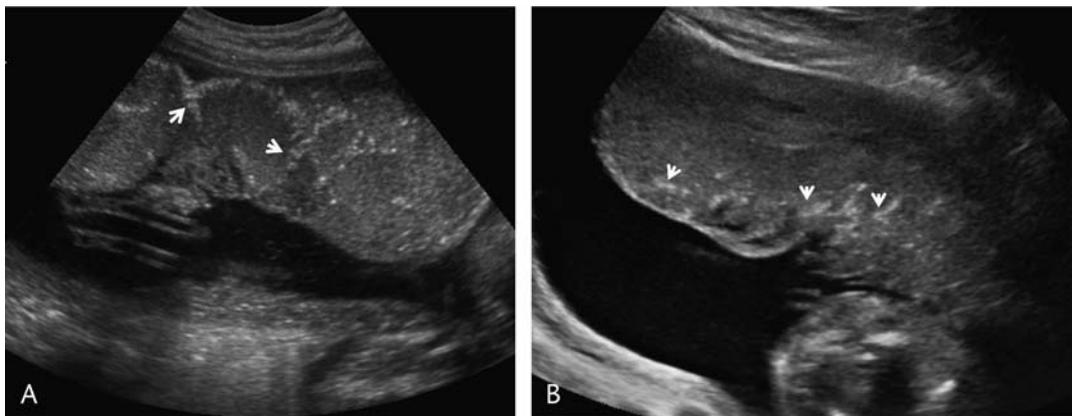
Placental calcification. A, Sagittal gray scale ultrasound image of a normal placenta at 35-week gestation shows calcifications (short arrows) in a “dot-dash configuration” along the basal plate outlining the cotyledons. B, Transverse gray scale ultrasound image of the placenta at 25-week gestation in a patient with preeclampsia shows premature calcification in a linear pattern suggestive of a distribution in vascular territories (short arrows).
